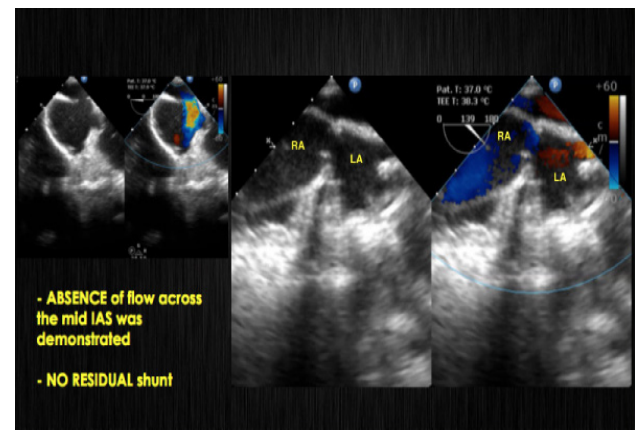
Post-operative transesophageal echocardiogram showing no residual shunt across the interatrial septum (IAS)
